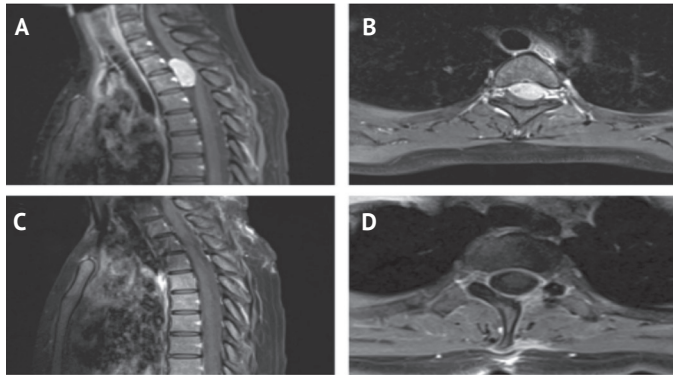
A 44-year-old female patient. A, B) A ventral intradural extramedullary tumor was detected at T2-T3 level on sagittal and axial preoperative T1-weighted contrast-enhanced MR images. C, D) Sagittal and axial postoperative T1-weighted contrast-enhanced MR images showed no residual tumor
